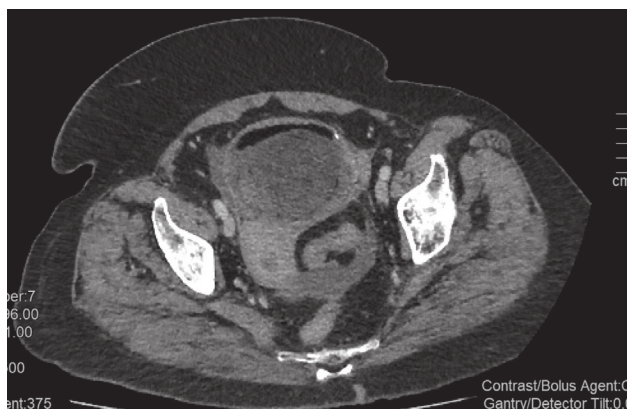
Axial computed tomography (CT) image demonstrating a well-defined heterogeneous mass with fat, soft tissue, and calcified components, consistent with a mature (benign) teratoma.
